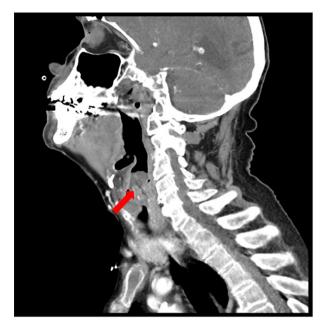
Sagittal CT obtained after abnormal findings noted on direct laryngoscopy showed a 3×2×2 cm supraglottic hypodensity (arrow), thought to represent a spontaneous retropharyngeal hematoma.
